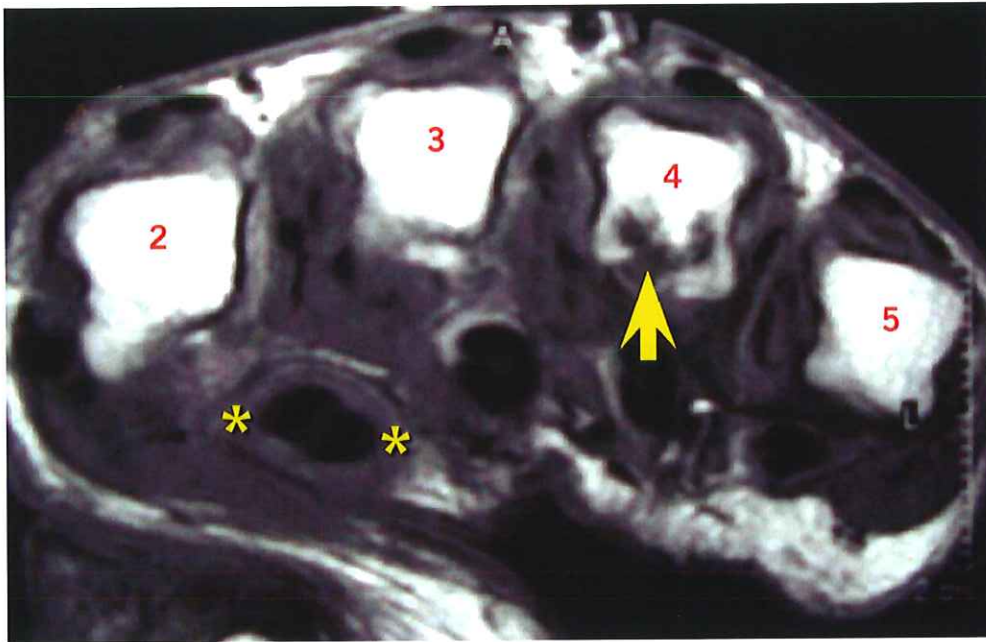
(b) Pre-gadolinium MRI of corresponding left 4th MCP joint with bone defect on volar aspect of MC head (arrow) and FT (*)
